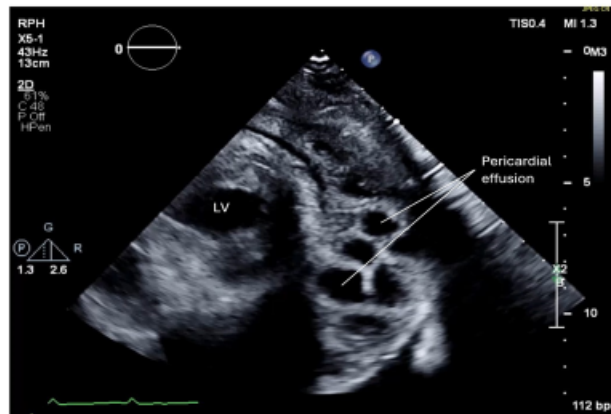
Parasternal short-axis view
